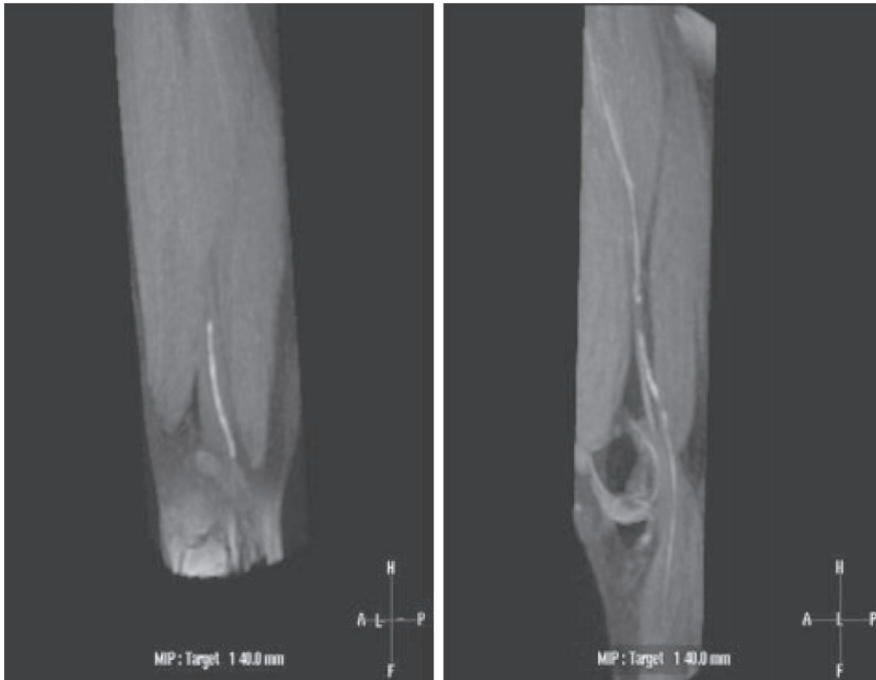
Left picture represents a sagittal reconstruction of MRDTI from a DVT of the left distal femoral and popliteal vein in a male patient with a retroperitoneal mass (not shown). At 5 months after the initial diagnosis oral anticoagulant medication was discontinued because of CT guided biopsy of the mass. This patient developed recurrent complaints of the left leg and compression ultrasonography and MRDTI showed an extension of the thrombus into the proximal femoral vein.
